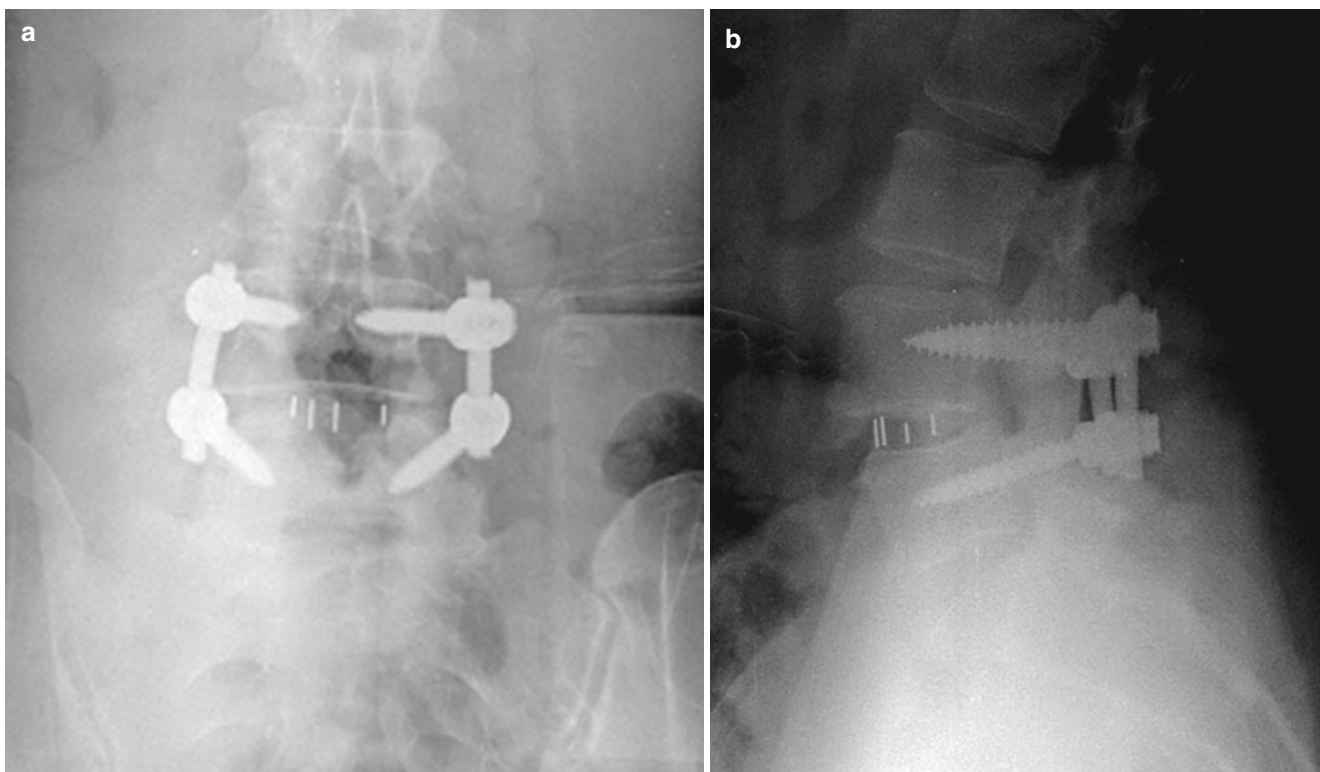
Postoperative anteroposterior (a) and lateral (b) lumbar plain radiographs in the patient from Fig. 13.6 who underwent a lumbar laminectomy and a posterior and transforaminal lumbar interbody
